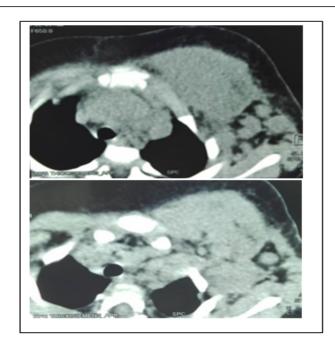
A mediastinal axial Computed Tomography showing an homogeneous left parietal mass opposite the left breast region with a densification of fat under jascente and subcutaneous axillary adenomegaly.
